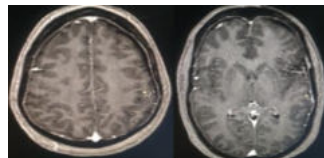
C, D-Post contrast axial sections T1W image of MRI brain -Diffuse bilateral symmetrical patchy meningeal enhancement & minimal bilateral subdural hygroma in fronto-parietal regions (Left> Right).
